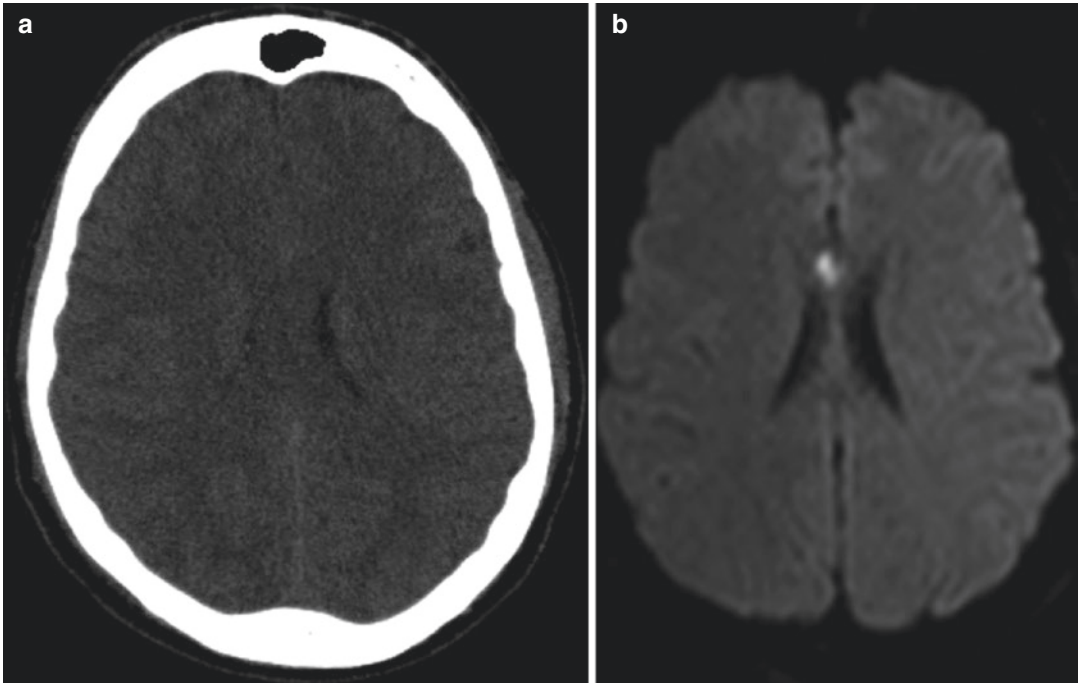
(a) CT scan; (b) DWI on axial plane. Presence of a restricted diffusion focal area located in the right portion of the corpus callosum, not identifiable on CT
